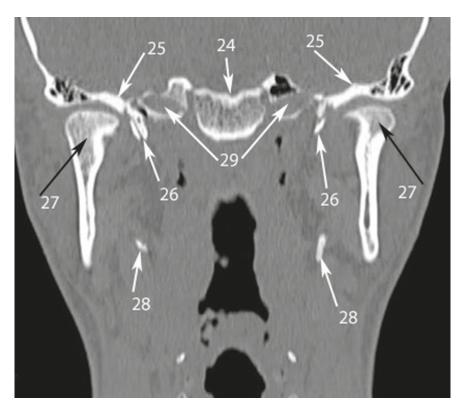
Coronal CT scan at the level of condylar processes. *Numbers* with *arrows* denote the following anatomical structures: 24 – basilar part of the occipital bone; 25 – greater wing of the sphenoid bone; 26 – pterygoid process of the sphenoid bone; 27 – condylar process of the mandible; 28 – styloid process of the temporal bone; 29 – carotid canal of temporal bone.
